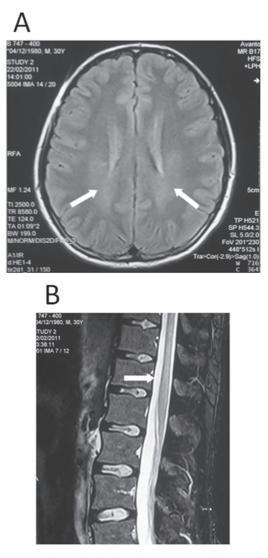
Brain and spinal cord MRI. A: Axial T2-weighted image showing increased signal in the parieto-occipital white matter bilaterally (arrows), indicating symmetrical demyelinating lesions. B: substantial atrophy of the thoracolumbar cord just above the conus medullaris (arrow) evident in a sagittal T2-weighted image.
